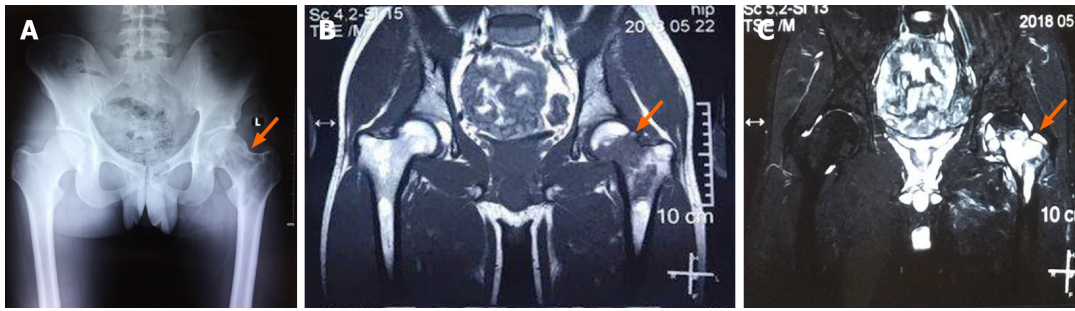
Plain X-ray and magnetic resonance imaging of the pelvis in a patient with bone epithelioid hemangioendothelioma. A: Bone destruction of the proximal femur on the left side; B: T1-weighted image showing the lesion in the left proximal femur side with low signal; C: T2-weighted image showing an obvious hyperintense signal in the left proximal femur.
